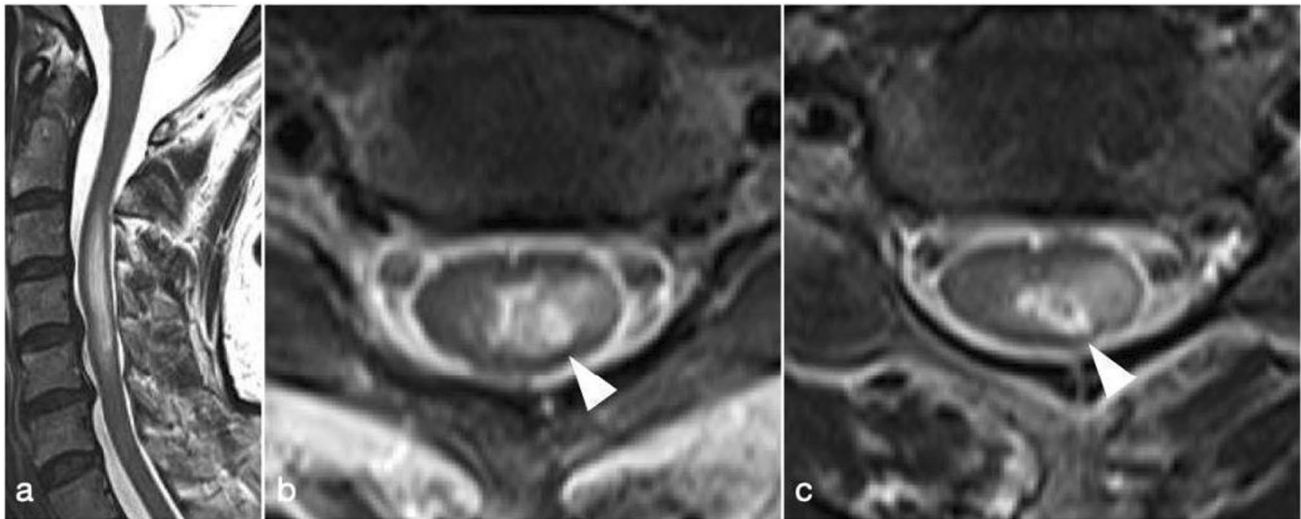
Spinal MRI 28 days after vaccination. a T2WI showed hyperintense lesions from the C3 to C5 level in the cervical spinal cord. b C3 level. c C5 level. The lesions were lateralized to left lateral column from the C3 to C5 level
